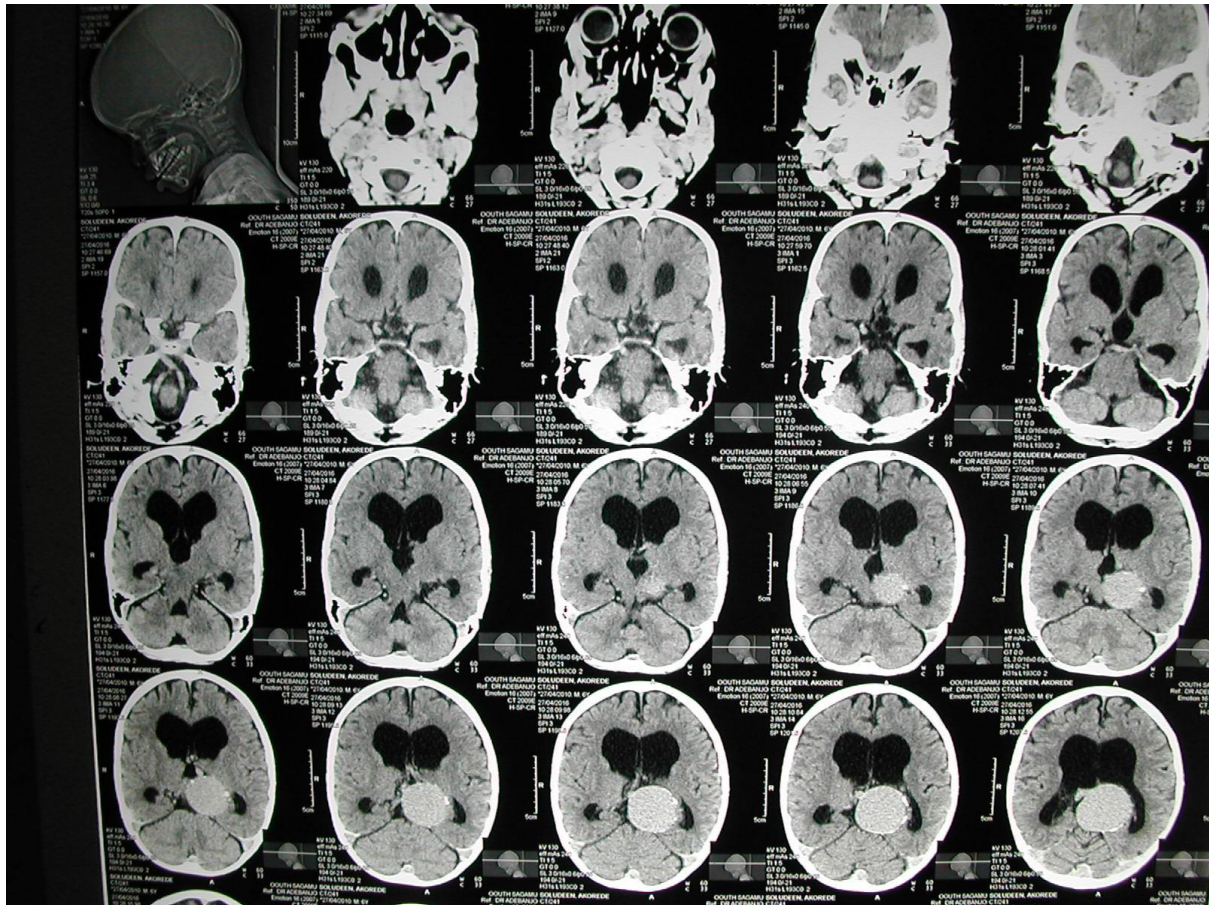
CT Scan showing dilated lateral ventricles along with an aneurysmal mass located in the pineal region
